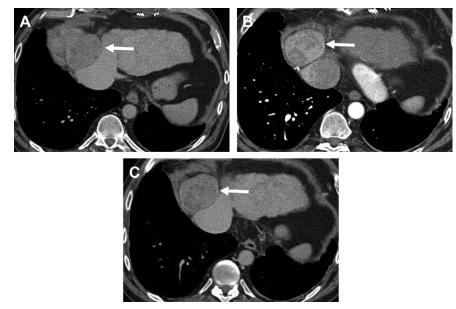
A 44-year-old man with history of tricuspid atresia status post-Fontan procedure. Axial unenhanced CT (*A*) shows a large hypoattenuating mass in hepatic dome (*arrow*). The lesion shows heterogeneous enhancement during the hepatic arterial phase (*B*) with subsequent washout during the venous phase (*C*). The lesion is heterogeneous and does not have central scar, unlike FNH-like nodules. Percutaneous biopsy was consistent with hepatocellular carcinoma.
